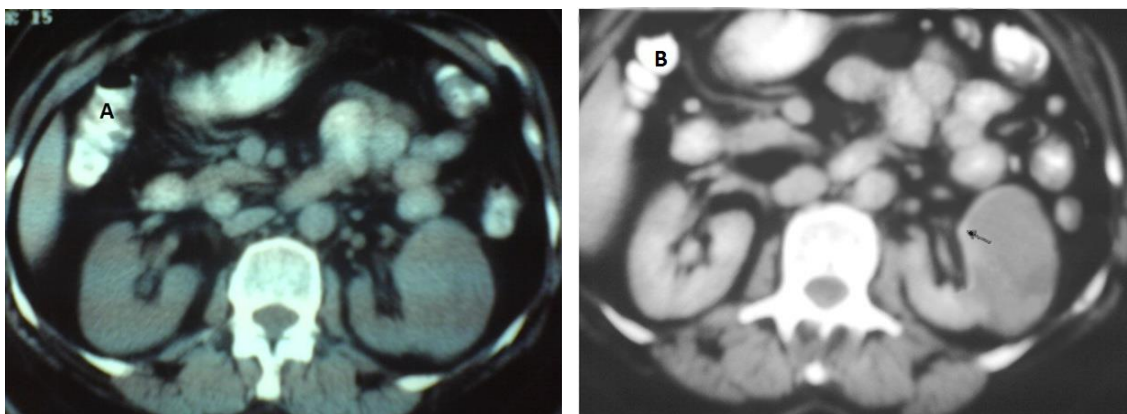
Computed tomography A) without contrast B) with contrast; complex cystic mass with thickened irregular walls, vascularity and relative enhancement (solid arrow) and attenuated fluid in the secretory phase without any organ involvement. Possible diagnosis was cystic renal tumor.
